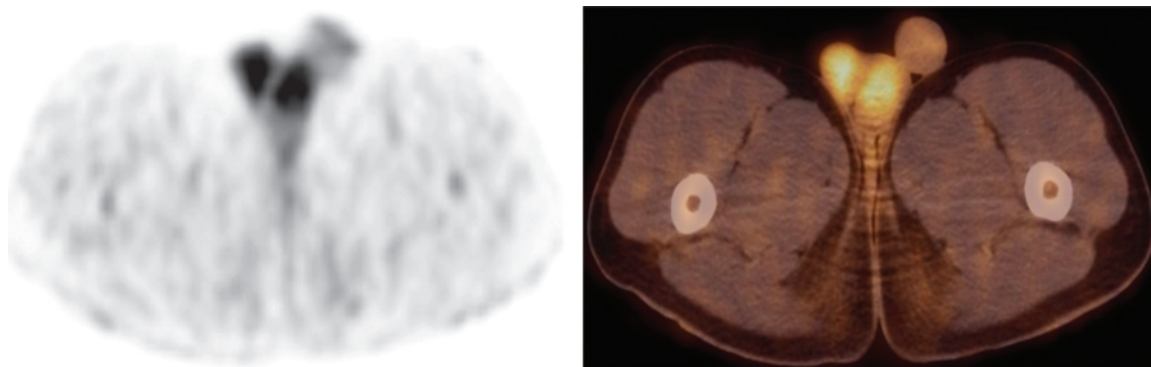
Physiologic testicular uptake in a 16-year-old boy with a history of lymphoma of the left tibia. Transverse ¹⁸F FDG PET scan (a) and fused PET/CT image (b) show moderate and diffuse uptake in the testicles. No abnormalities were seen at CT.
